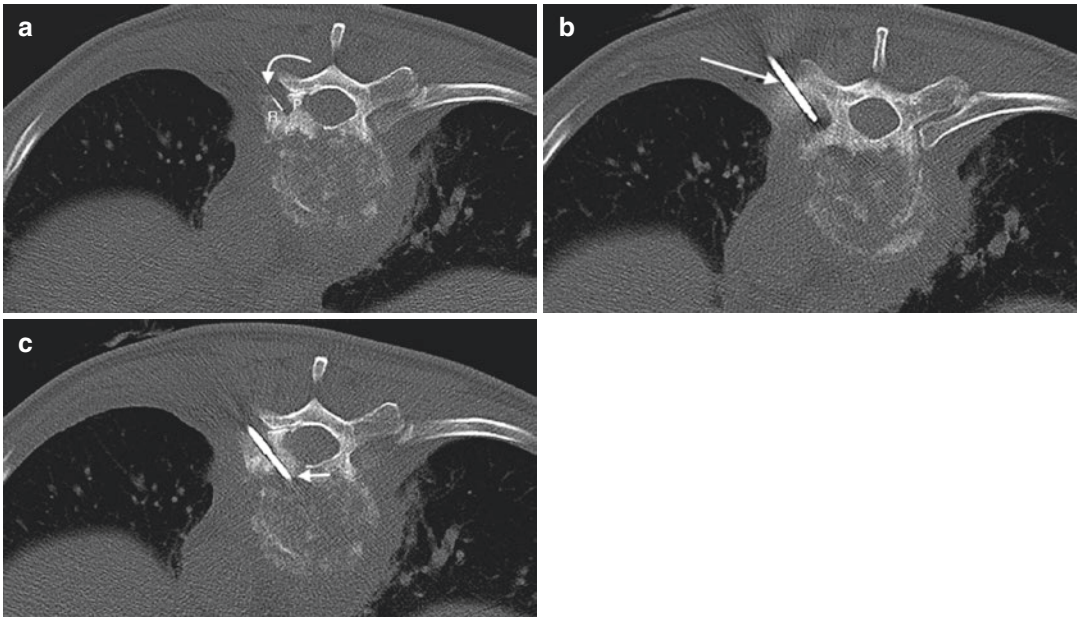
A 59-year-old male with a history of previously treated *Streptococcus anginosus* infectious spondylitis at T9-T10 presents with back pain and elevated ESR and CRP. Axial CT image (a) acquired during biopsy shows a spinal needle (curved arrow) entering the groove between the pedicle (P) and rib (R), a transcostovertebral approach.
